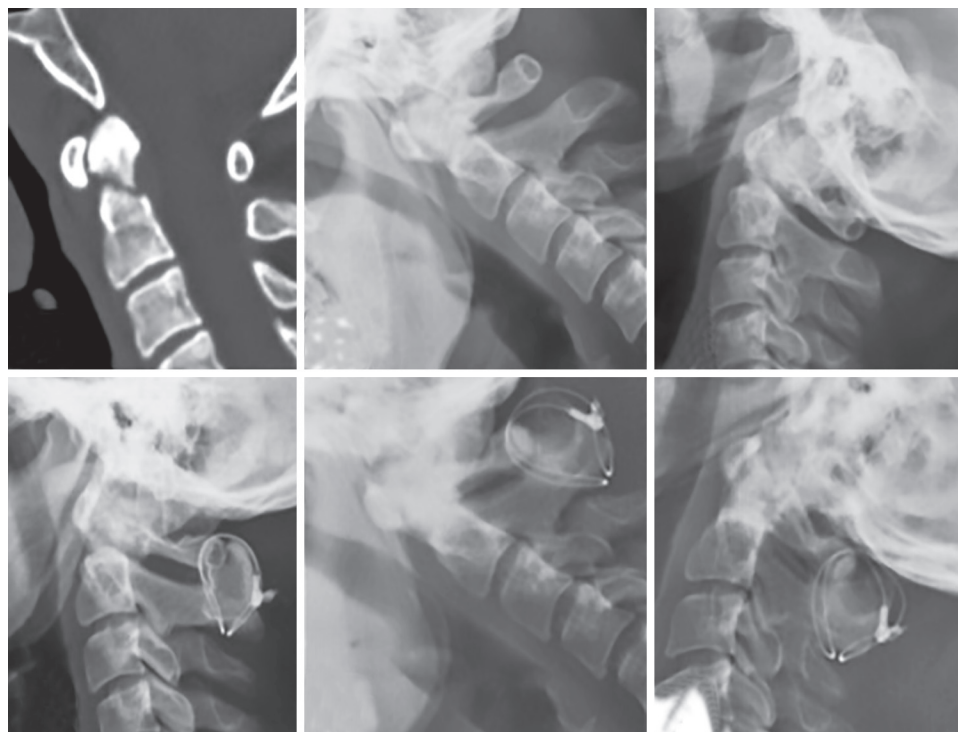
25-year old male with a minimally displaced type II odontoid fracture.(a) Preoperative CT sagittal images of the cervical spine. Preoperative flexion (b) and extension (c) radiographs showed no significant movement. As he had severe neck pain and restriction of neck movement, he was offered surgery and underwent a C1-2 modified Brook's fusion. (d) Immediate postoperative lateral radiograph showing the construct in situ. 1 year follow-up lateral radiographs showing bony fusion and no instability on flexion (e) and extension (f) images.
